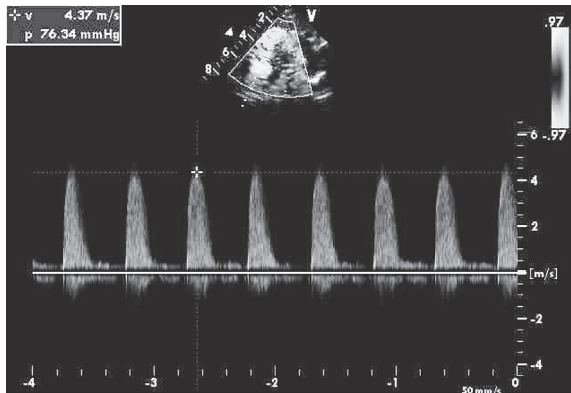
Continuous wave Doppler at aortic valve in the suprasternal notch view
